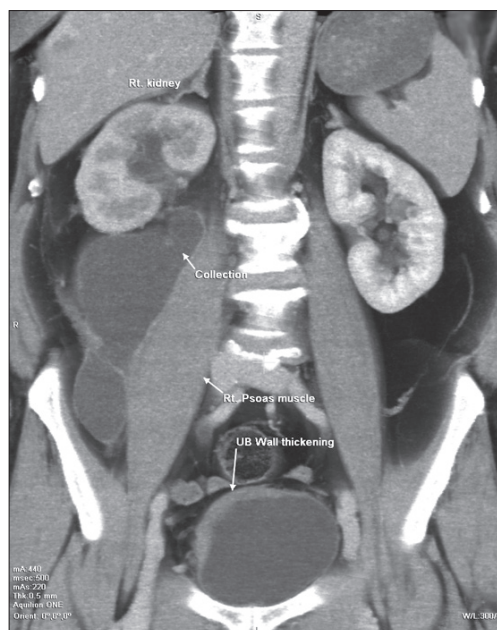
CT scan abdomen reconstruction showing right sided hydronephrosis with right urinary extravasation from the ureter and thickening of the right lateral wall of the bladder
